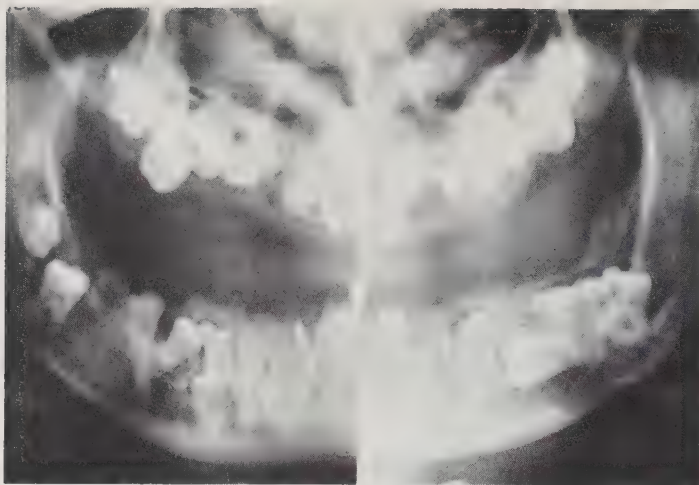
Panoramic radiograph of Case 1, an 18 year old man.
